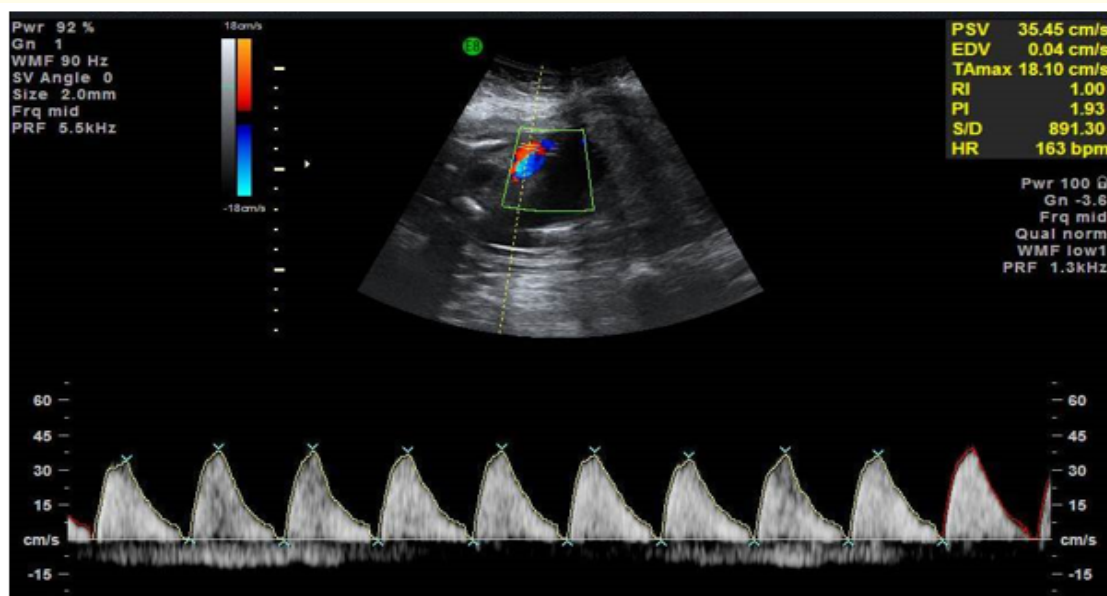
Color Doppler umbilical artery wave form demonstrating absent end diastolic frequency. This is less severe by comparison with figure 2.
